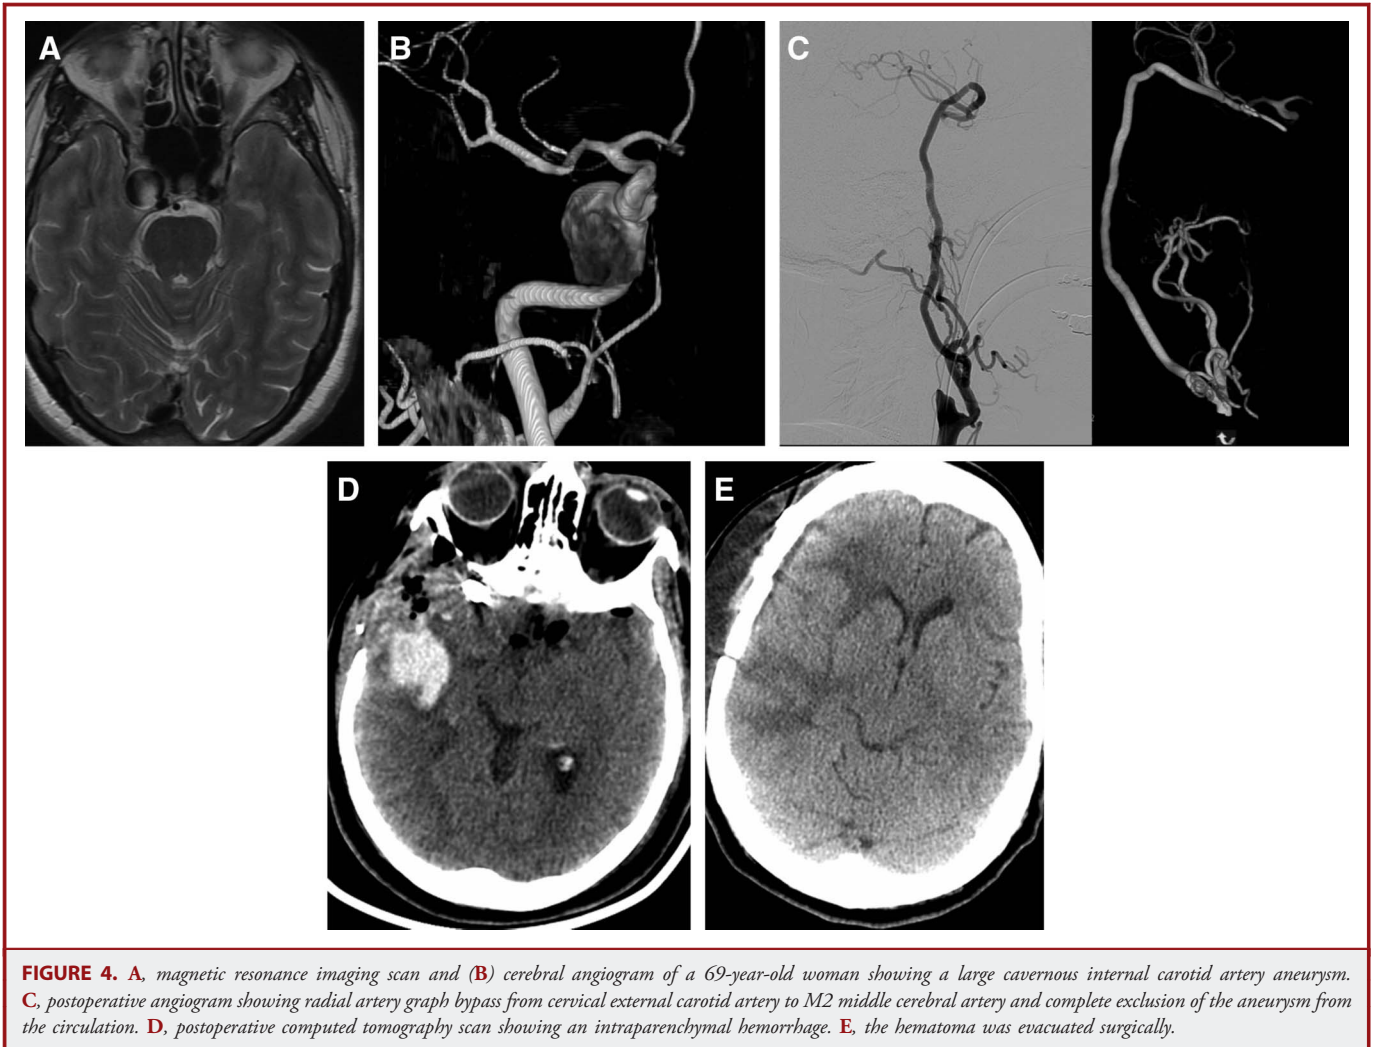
A, magnetic resonance imaging scan and (B) cerebral angiogram of a 69-year-old woman showing a large cavernous internal carotid artery aneurysm. C, postoperative angiogram showing radial artery graph bypass from cervical external carotid artery to M2 middle cerebral artery and complete exclusion of the aneurysm from the circulation. D, postoperative computed tomography scan showing an intraparenchymal hemorrhage. E, the hematoma was evacuated surgically.
